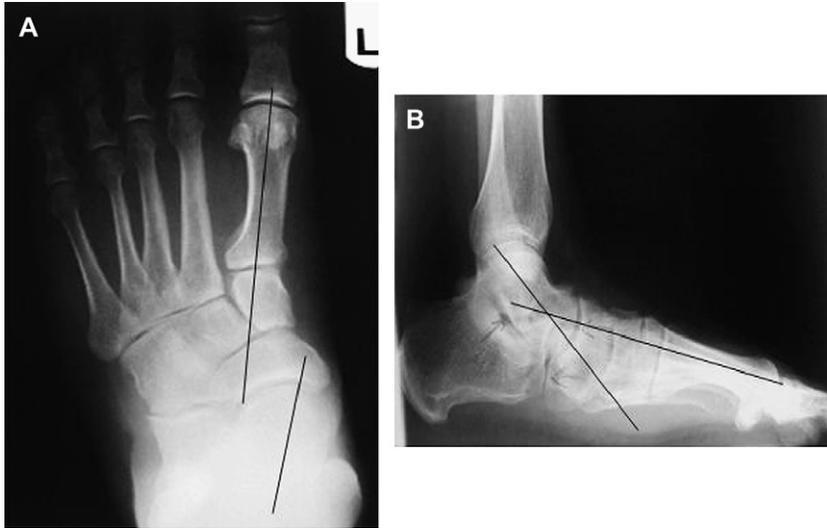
(A) Anteroposterior view of left foot demonstrating talar head uncovering, increased talo-first metatarsal angle (Simmon's angle), and increased cuboid abduction angle. (B) Lateral radiograph of the left foot demonstrating decreased calcaneal inclination angle, increased talar declination angle, and increased talo-first metatarsal angle (Meary's angle).
